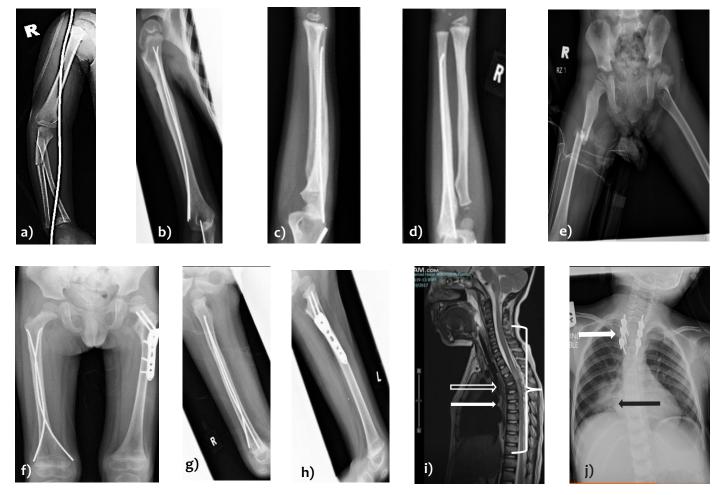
(a) The X-Ray shows a segmental ulna and distal third right radius with proximal third humerus fracture, (b) X-ray of the humerus fracture that was addressed using Titanium Elastic Nails (TENS) three months after surgery show united fracture, (c) and (d) Postoperative anteroposterior and lateral x-rays of the radius-ulna taken three months after surgery demonstrated union of the fractures. TENS nail was used to fix the ulna while k-wires that was used to fix the radius had been removed at six weeks post fixation, (e) The immediate anteroposterior pelvic radiograph displays right proximal third and left subtrochanteric fractures, (f), (g) and (h) postoperative anteroposterior and lateral views of bilateral femur x-rays performed three months post-surgery demonstrating fractures union, (i) sagittal cut of the upper spine Magnetic Resonance Imaging (MRI) shows spinal epidural hematomas from T1-T12 (white brace), worst at T3-T5 (white arrow) level causing spinal compression (j) Posteroinferior chest x-ray views show consolidation at right middle and lower zone of the lung (black arrow) corresponding with nosocomial pneumonia, with spinal instrumentation implants in situ (white arrow).
